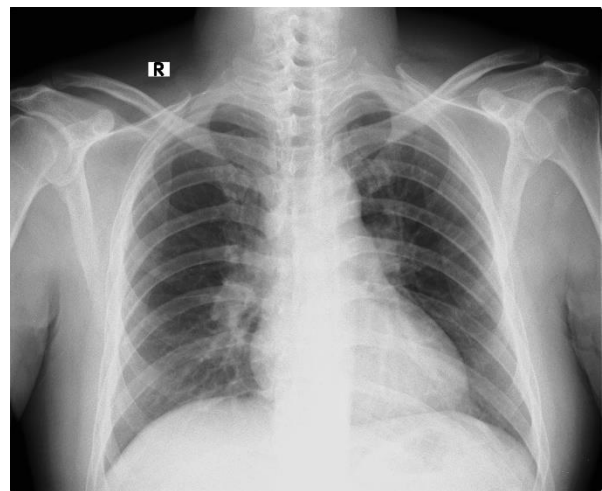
On admission Chest X-Ray showing no abnormality
